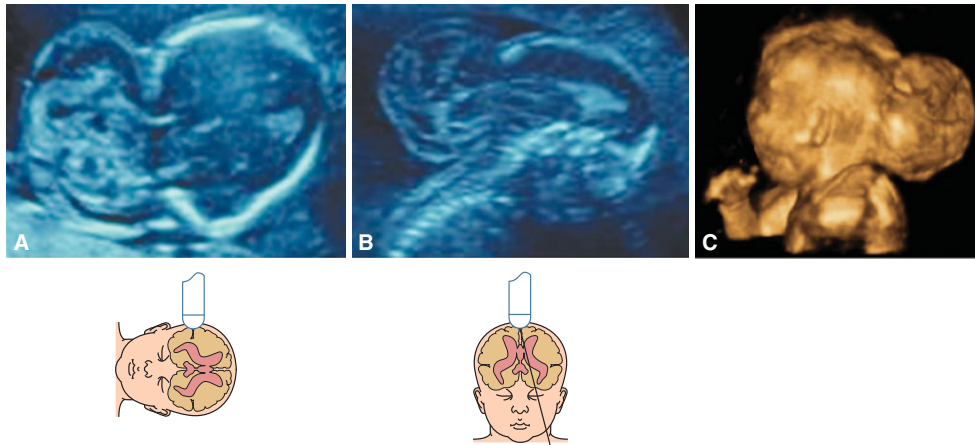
Using transabdominal sonography, a large posterior encephalocele is seen in this fetus at 19 postmenstrual weeks. (A) An axial section displays the large cephalocele sac. Brain tissue is seen extending into the sac. (B) Sagittal section displays the encephalocele. (C) A 3D reconstruction of the posterior encephalocele.
